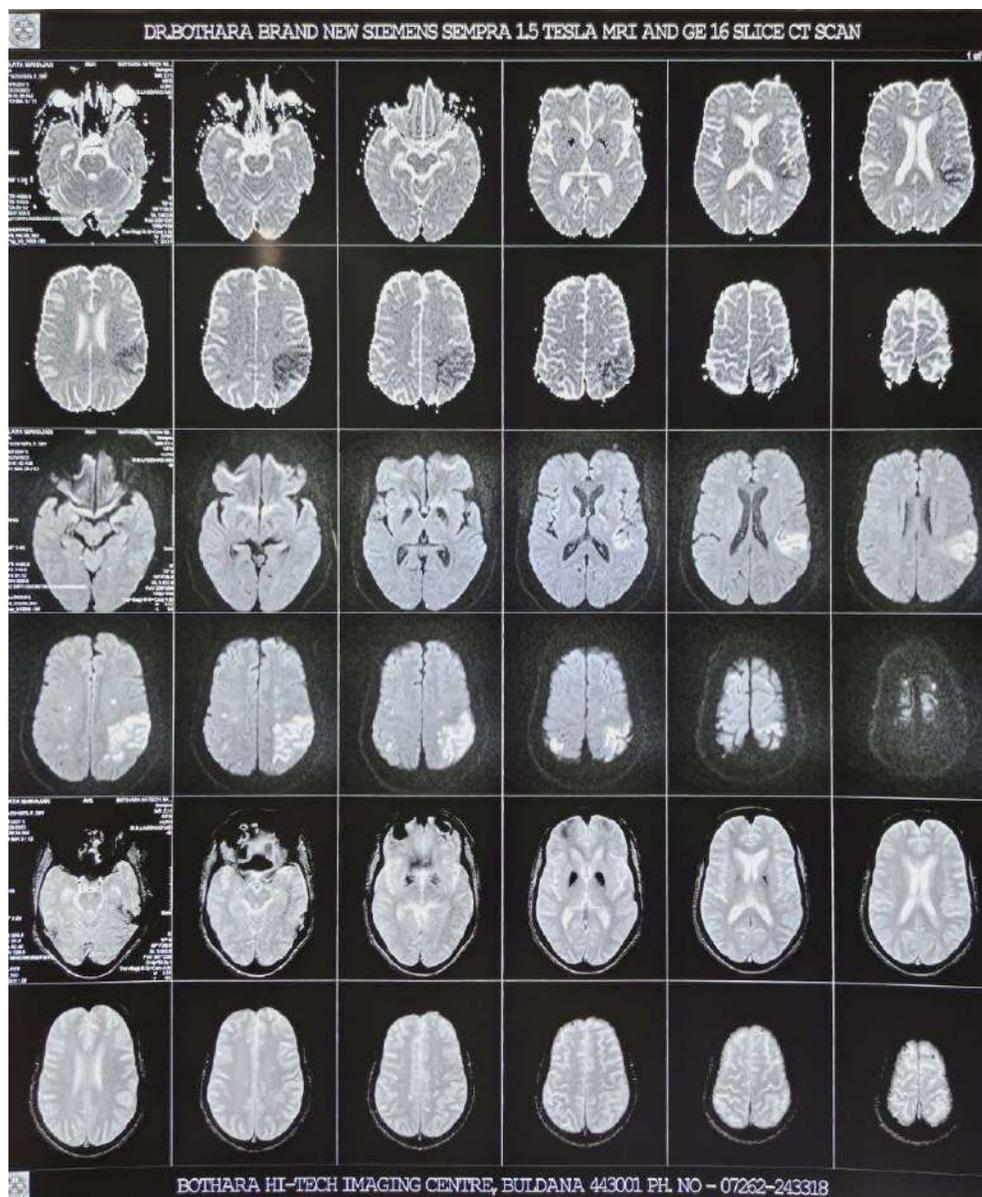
MRI with dwi/swi/gre sequencing.
